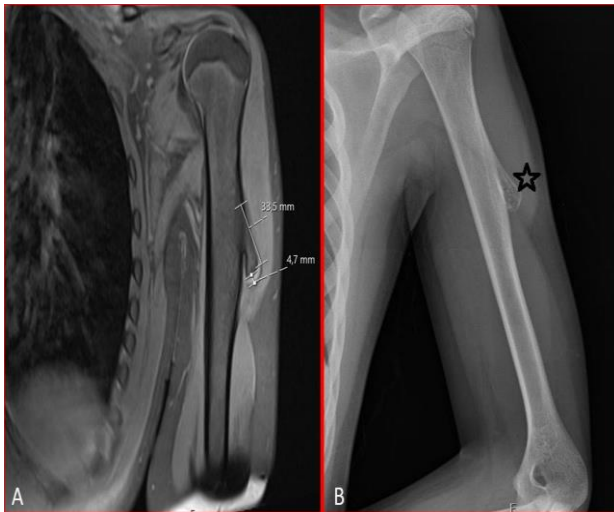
Image A: In a 9-year-old male patient, a 33.5 mm lesion with cortical continuity and bone marrow extension, consistent with a bony protrusion, is observed in the proximal diaphyseal region of the left humerus. On the T1-weighted fat-suppressed MRI image of the humerus, a cartilage cap measuring approximately 4.7 mm is distinguishable. Image B: Anteroposterior radiograph of the same patient's humerus. A bony mass with cortical continuity is evident on the lateral aspect of the humeral diaphysis (marked with a star).
